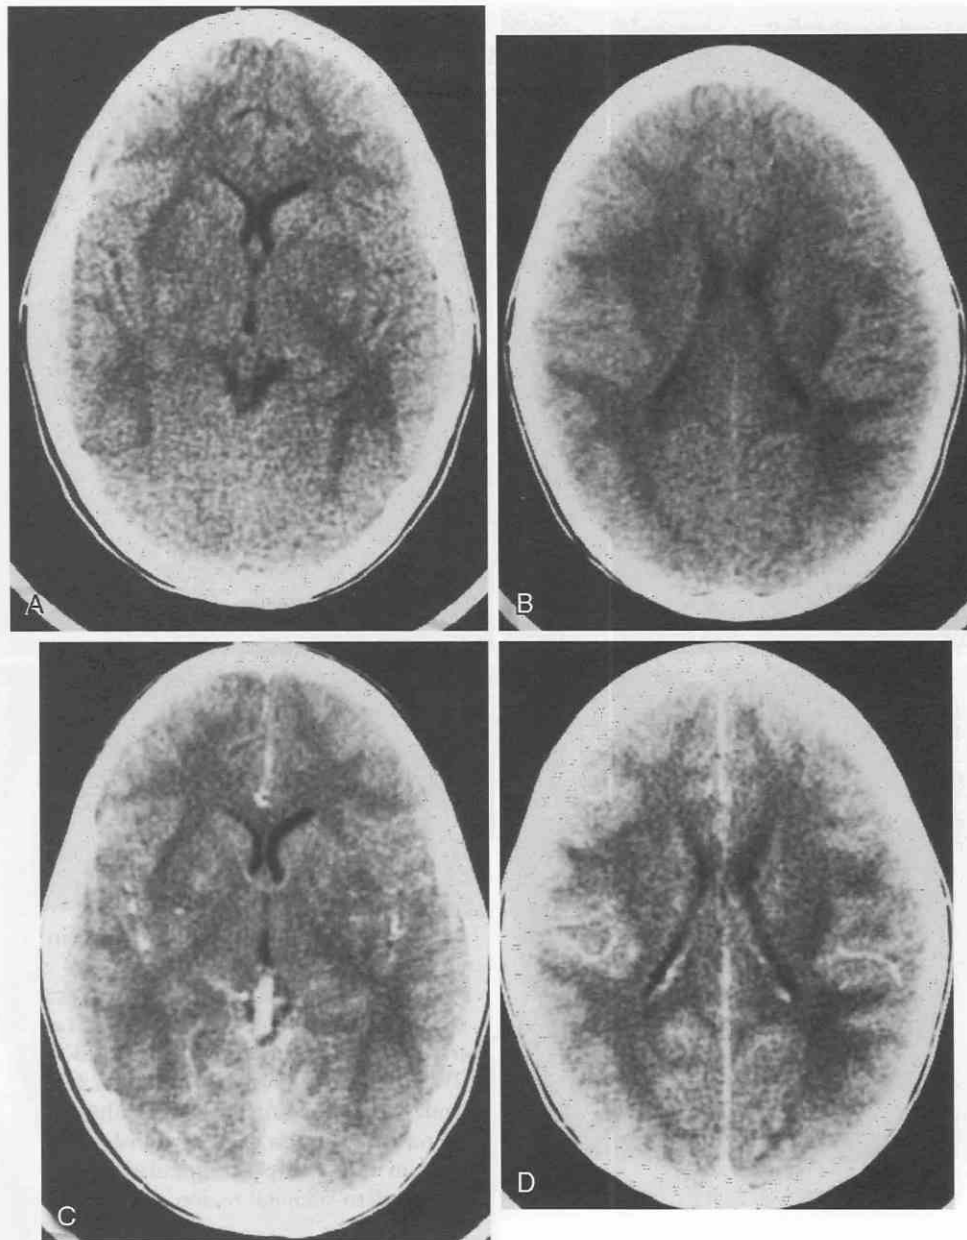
Acute disseminated encephalomyelopathy (ADEM). A and B, Non-contrast-enhanced CT scans demonstrate multifocal white matter lucencies, most visible in the basal ganglia bilaterally as well as in the parieto-occipital white matter. C and D, There is no contrast enhancement. The multiplicity of lesions is typical.
